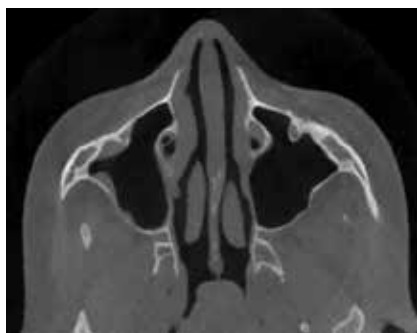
Axial section of CBCT, showing sinus mucosal thickening in the right maxillary sinus.
